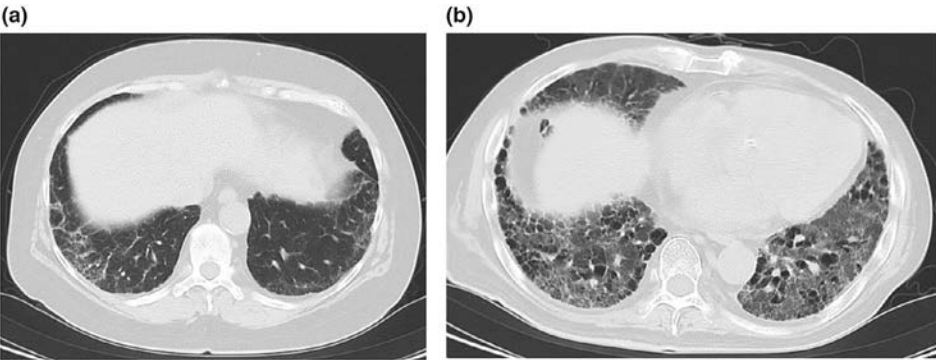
Representative chest CT image of (a) interstitial lung abnormality and (b) interstitial lung disease in a patient with rheumatoid arthritis. (a) Chest CT demonstrates subtle peripheral and basal reticular abnormalities consistent with an interstitial lung abnormality. (b) Chest CT demonstrates advanced fibrotic interstitial lung disease with bilateral honeycombing, consistent with interstitial lung disease.
